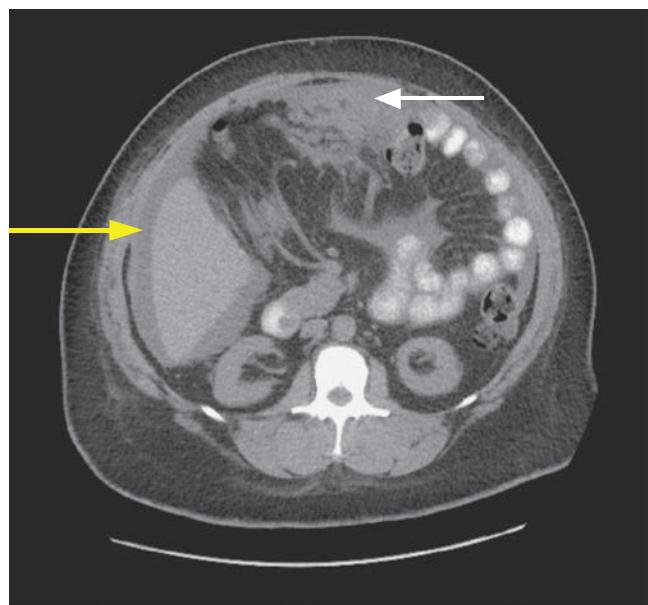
CT of a patient with peritoneal carcinomatosis (white arrow) and ascites (yellow arrow).
